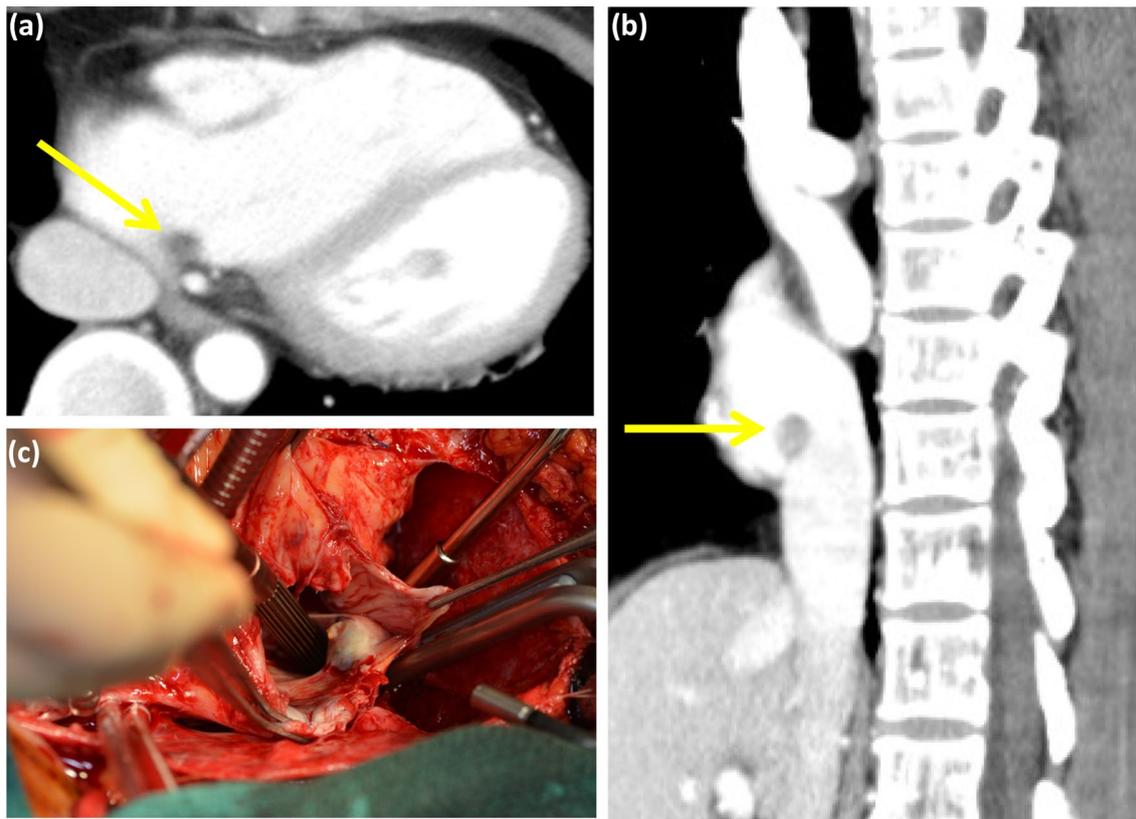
Axial and sagittal view of enhanced computed tomography revealed that there was a tumor near the inlet of inferior vena cava in the right atrium. There were no recurrence of tumor in other cardiac
